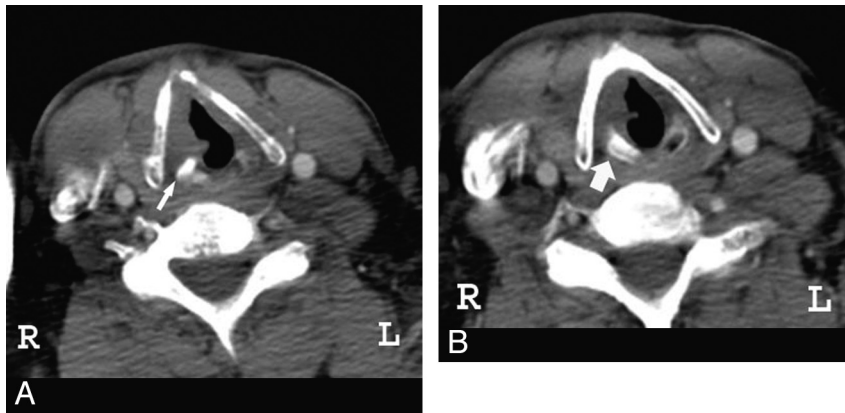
False-positive samples. A, Sclerosis of the right arytenoid cartilage on an axial CT scan obtained at the glottic level (thin arrow). B, Sclerosis of the cricoid cartilage on an axial CT scan obtained at the subglottic level (thick arrow).
